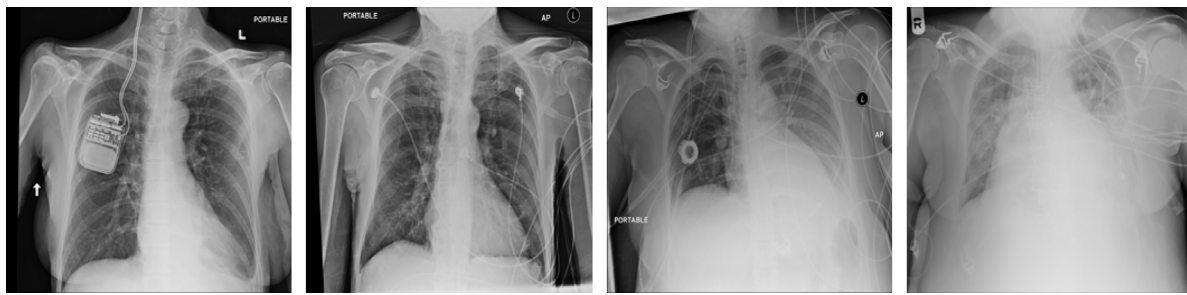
Examples of chest X-ray images with artifacts and bad quality captures.
